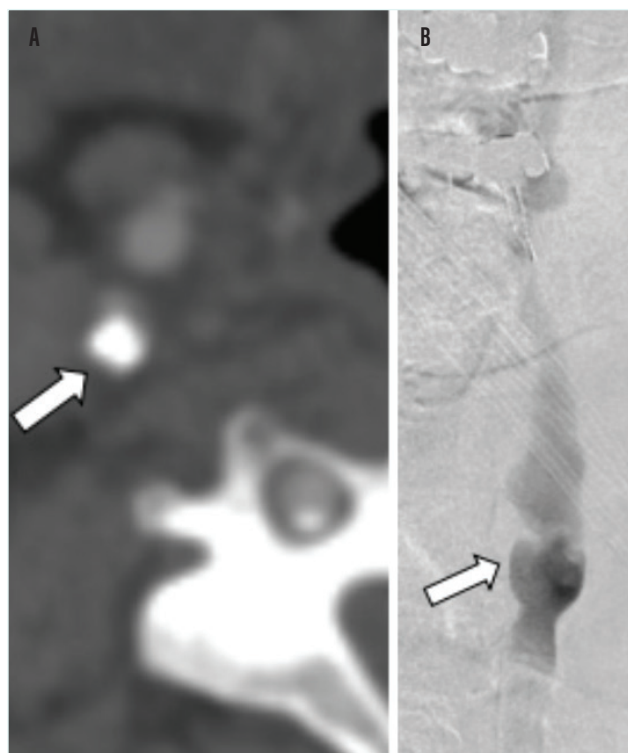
CT angiogram image of a proximal internal carotid lesion (arrow) with minimal calcium and of relatively short length (A). Intraoperative digital subtraction angiography of the same carotid lesion (arrow). Note: the wire is traversing the ascending pharyngeal artery, which typically mirrors the course of the internal carotid artery (B). However, the ascending pharyngeal artery does not demonstrate a right angle turn (asterisk) at the petrous ridge, and thus special attention must be made in this scenario to advance the wire to the distal internal carotid artery to ensure accurate stent placement in the internal carotid artery. Successful stent placement across the internal carotid lesion (arrow) via TCAR (C).
